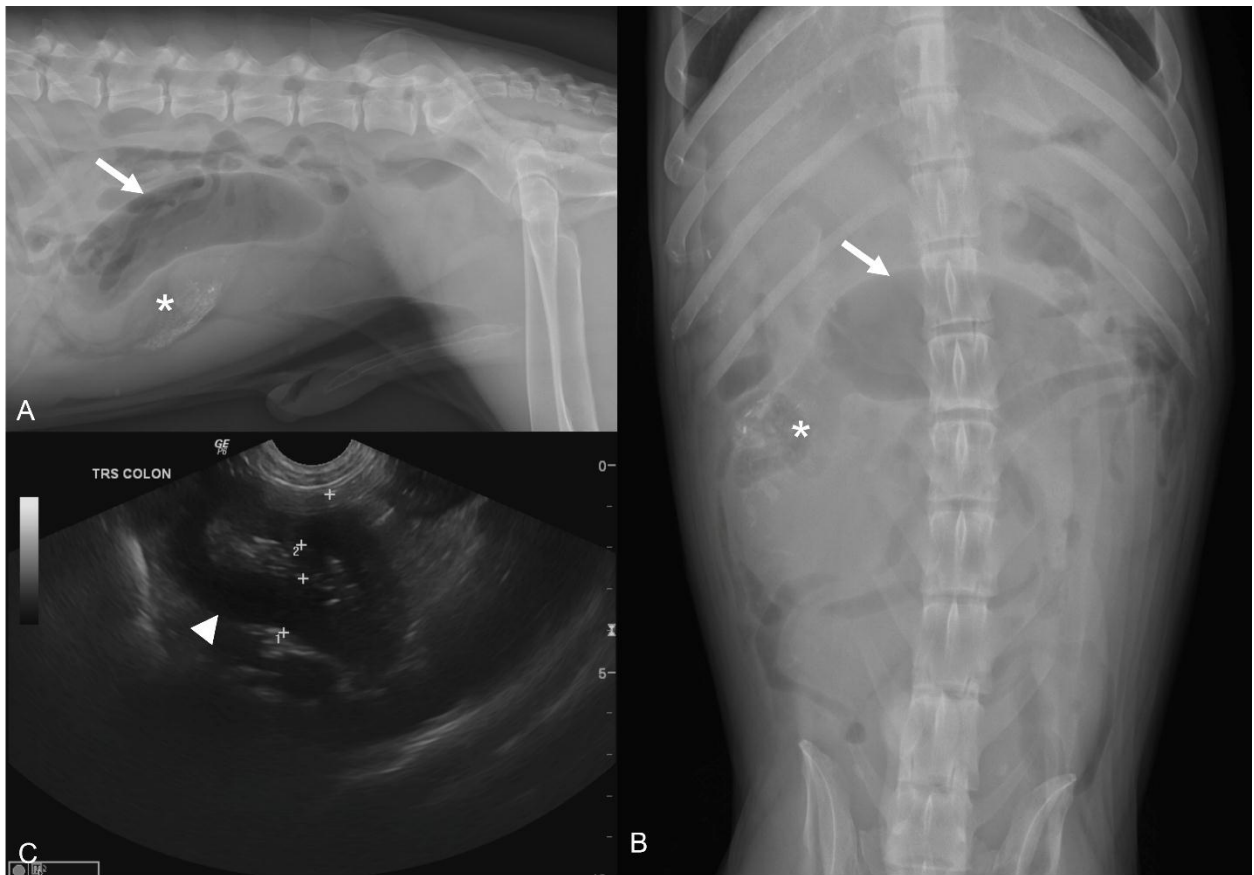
The right lateral (A) and ventrodorsal (B) abdominal radiographs showed focal intestinal ileus (arrow) with multiple small pieces of radiopaque foreign body (asterisk) indicating chronic partial obstruction of the small bowel intestinal loops and the transabdominal ultrasound (C) revealed intramural thickening with loss of wall layering at the transverse colon (arrow head).
